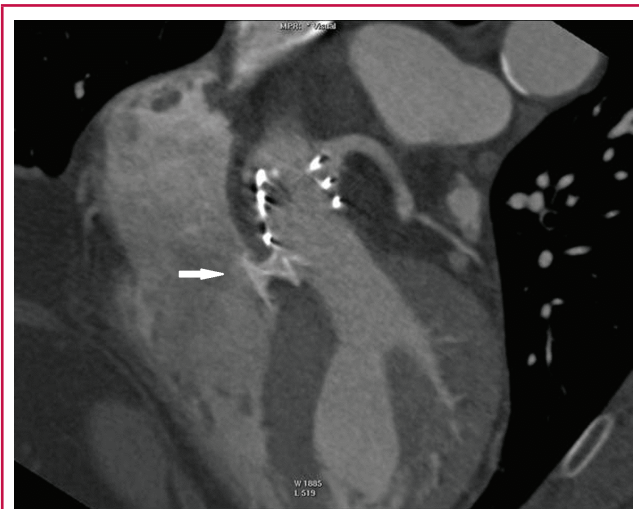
Cardiac CT after occlusion of the ventricular septal defect (white arrow pointing at the occluder). There is no interference between the Amplatzer occluder and Edwards Sapien XT prosthesis.
